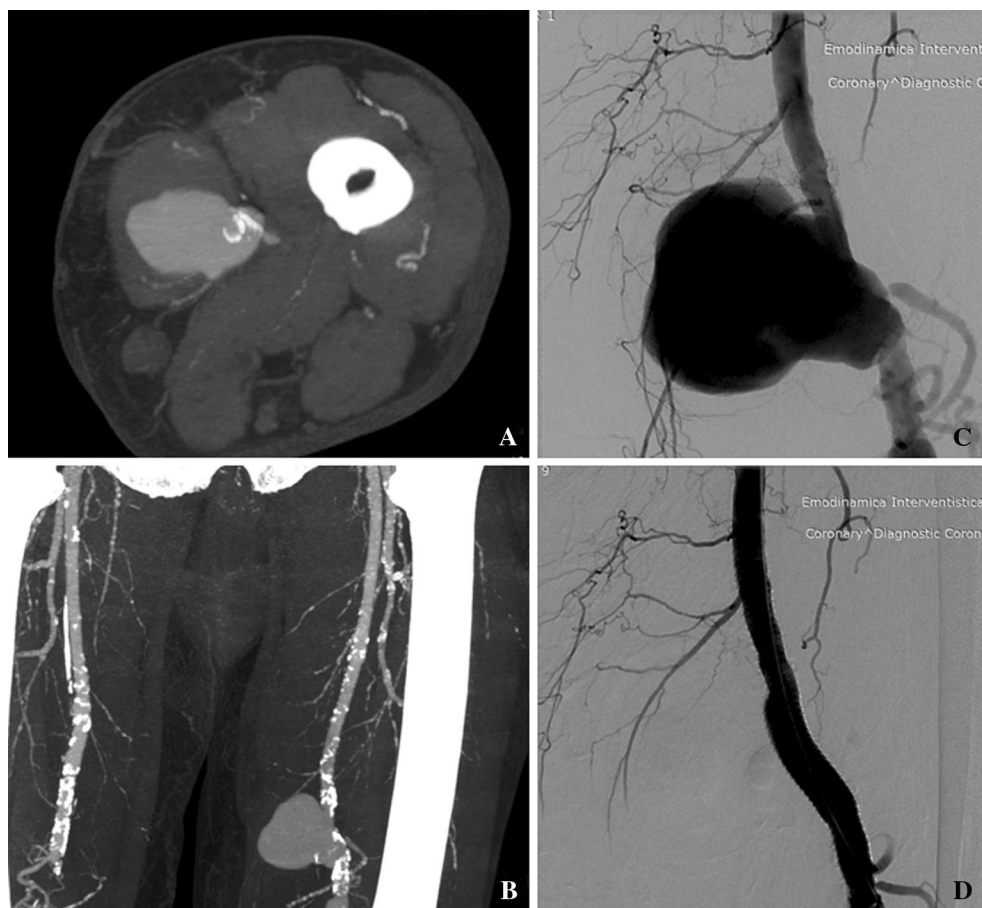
Transverse (A) and maximum intense (B) projection preoperative CT angiography images showing superficial femoral artery aneurysm. C Intraoperative frontal view arteriogram. Superficial
